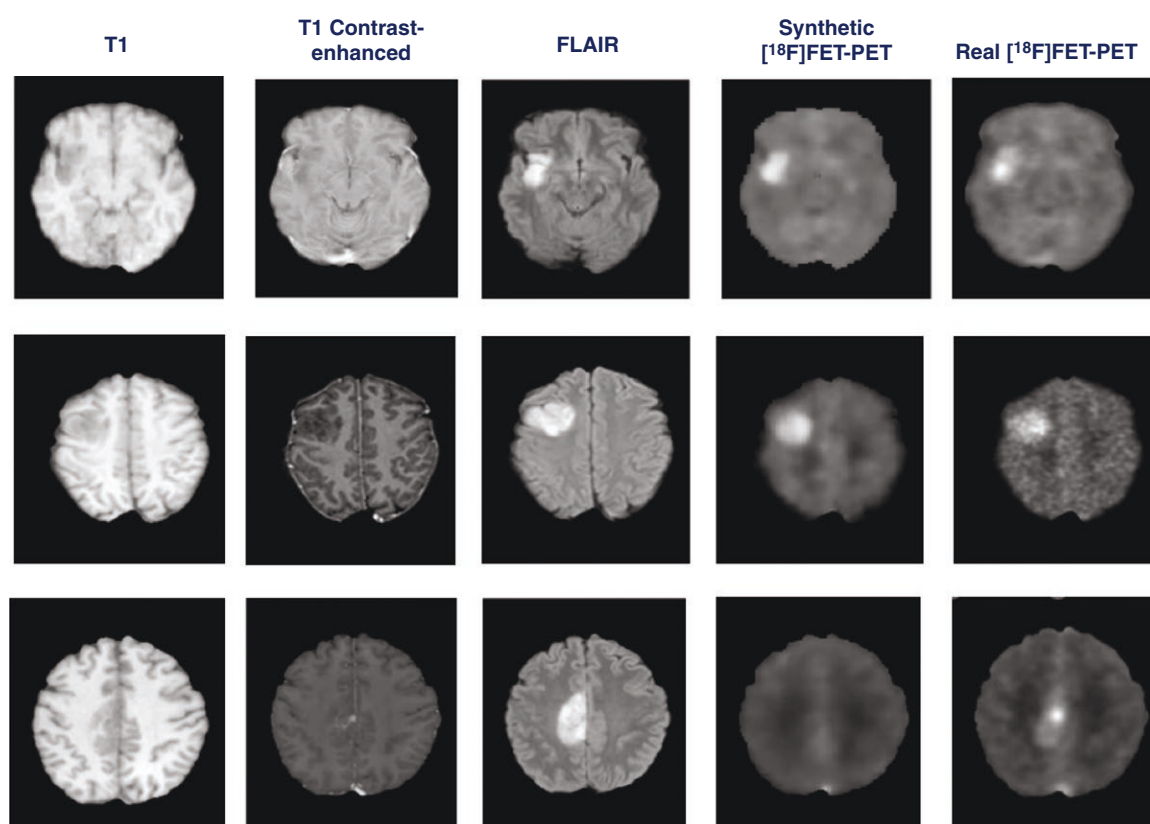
Representative cases of MRI-based synthetic ^{18}F FET-PET: 2 accurate reconstructions (first 2 rows) and an example of underestimation of FET uptake (last row). Abbreviations: ^{18}F FET = O-(2- ^{18}F -fluoroethyl)-L-tyrosine; MRI = magnetic resonance imaging; PET = positron emission tomography.
